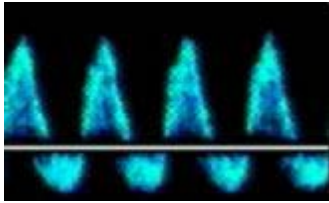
The Umbilical Artery Doppler Waveform Patterns:<sup>61</sup>
